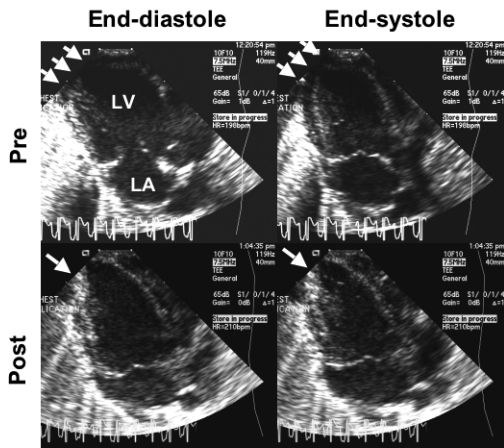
Echocardiograms before and after the left ventricular reconstruction (LVR) procedure. Multiple arrows in the pre-plication indicate the infarcted region. The single arrow in post-plication corresponds to the plicated hyperechogenic region. LA indicates left atrium; LV, left ventricle; Pre, pre-LVR or pre-plication; Post, post-LVR or post-plication.
